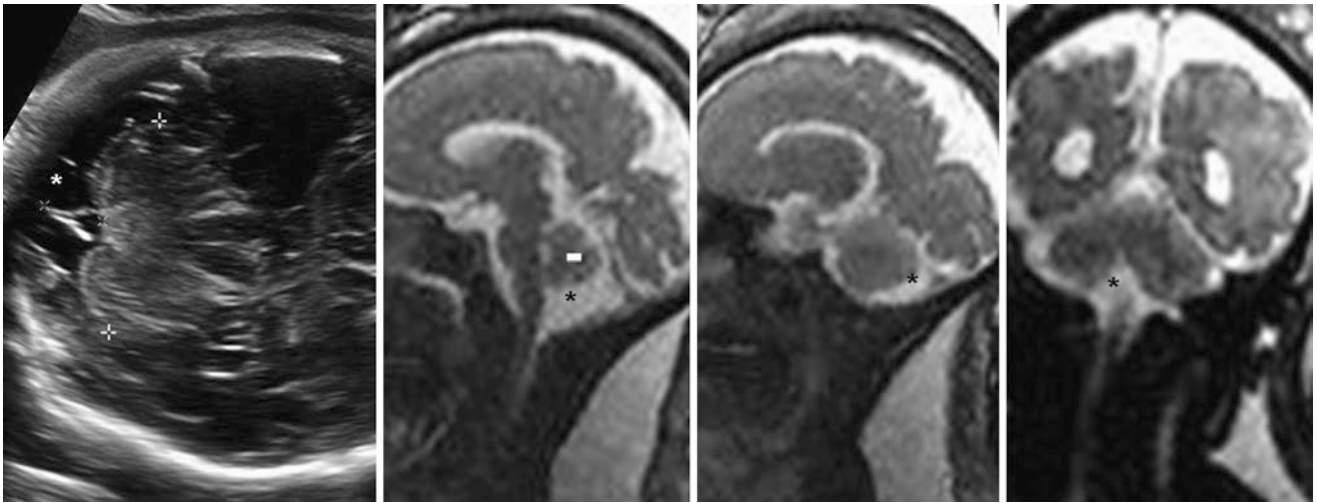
A 34 week gestational age fetus was shown to have a prominent retrocerebellar space (*) on axial ultrasound (*left, face is at the right side of the image*); the cisterna magna measured 11.2 mm (10 mm is upper normal at ultrasound). A midline fetal MRI image in the sagittal plane on
